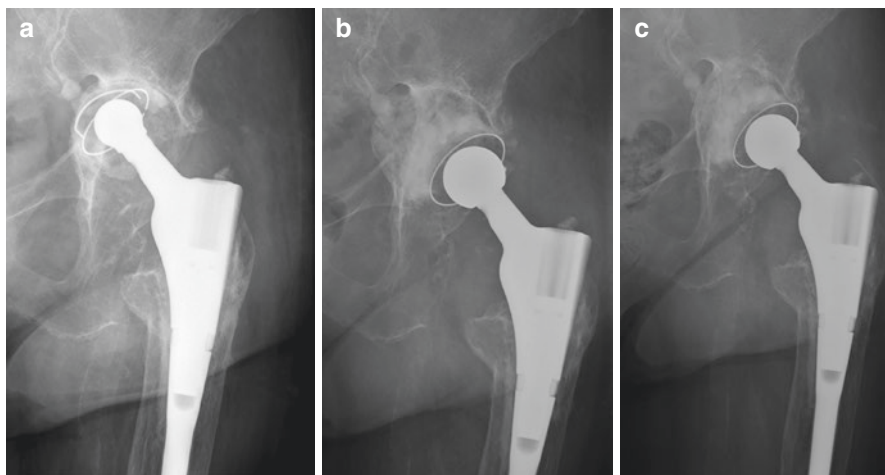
(a) Anteroposterior radiograph of hip shows a cemented loosened cup. (b) Postoperative radiograph 3 months after impacting allograft bone grafting with a cemented cup used in revision surgery. (c) Radiograph three years after operation. We can follow remodelling of the allograft
